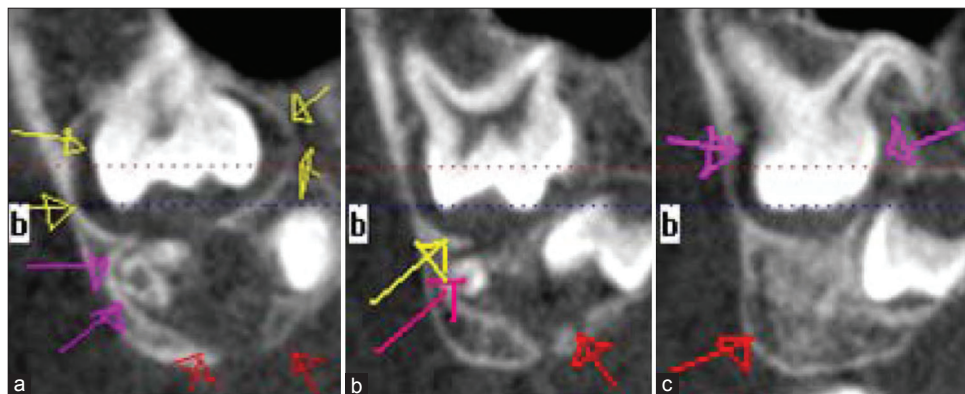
(a-c) 2 mm cuts radiographic view showing the impacted maxillary right primary second molar, radio-opaque mass (odontoma) was present above the crown of the maxillary right primary second molar and the crown of the maxillary right second premolar in addition to the cystic lesion (radiolucent area)
